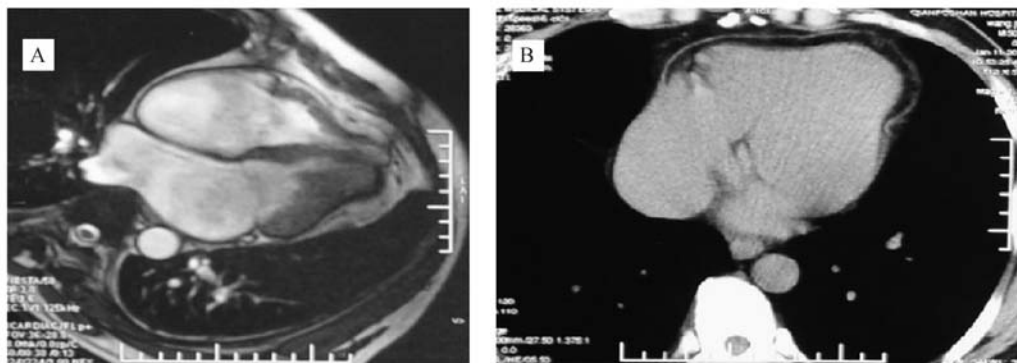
(A) MRI showed a narrow, tubular deformation of the lower bi-ventricular that coincided with the echocardiography findings. The thickness of the pericardium was normal and calcification was not observed. (B) CT revealed gourd-shaped ventricles. The pericardium thickness was normal. CT, computed tomography; MRI, magnetic resonance imaging.
